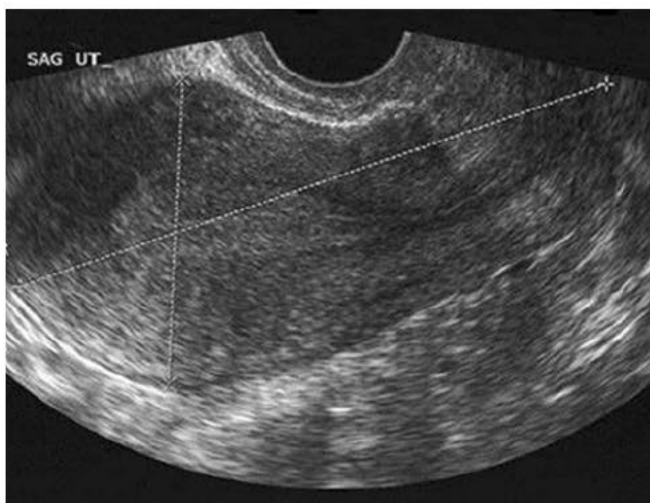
Transvaginal sonogram in the sagittal plane of an anteverted anteфлекted uterus. Calipers demonstrate measurements of the uterine length (+) and the anterior-posterior dimension (x).
